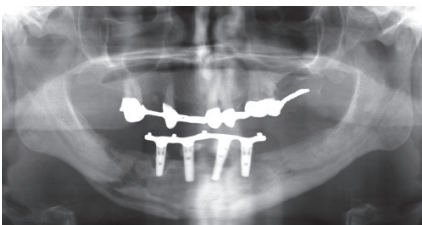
Panoramic radiograph Stage 3 MRONJ: Severe peri-implantitis around the 4 implants with horizontal and vertical bone loss, osteolysis and sequestra throughout the mandibular body extending to the inferior border. Subperiosteal bone formation is visible.
